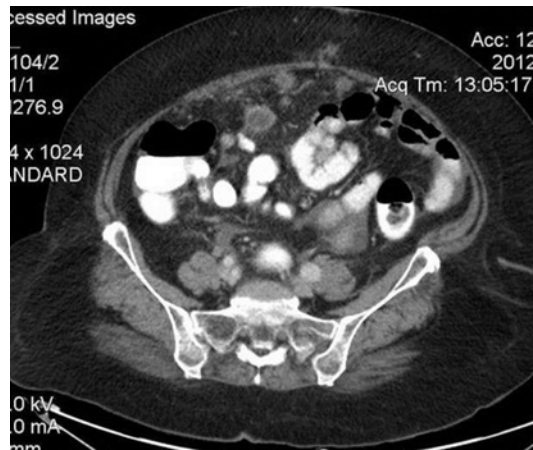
Contrast-enhanced axial CT showing soft tissue deposits with necrotic areas in the omentum suggestive of omental deposits
